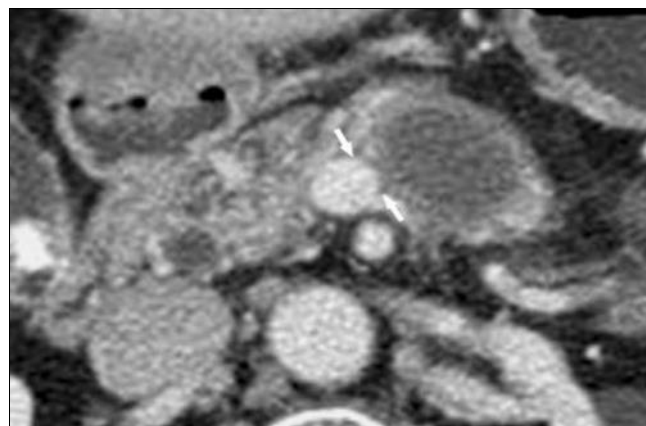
CT image shows a tumor in the body of the pancreas
